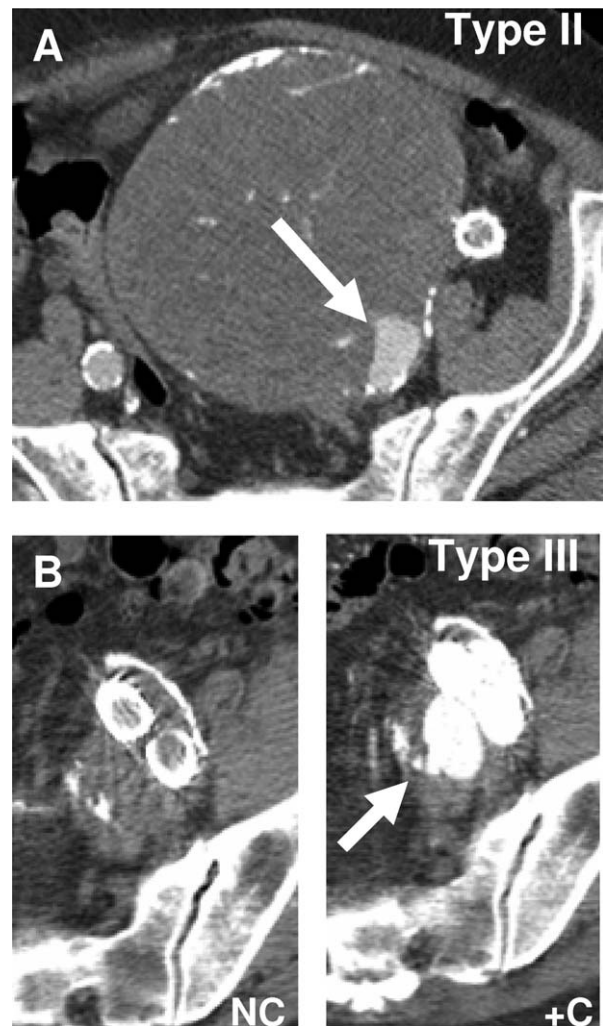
A, A Computed tomography angiogram (CTA) performed 6 months after endovascular repair of a 12-cm internal iliac artery aneurysm (IAA) shows a type II endoleak (arrow). B, In a CTA performed 3 years after endovascular repair of a left common IAA/internal IAA with two overlapping stent-grafts, a disconnection is seen on noncontrast CT resulting in a type III endoleak (arrow). NC, Noncontrast; +C, with contrast.
